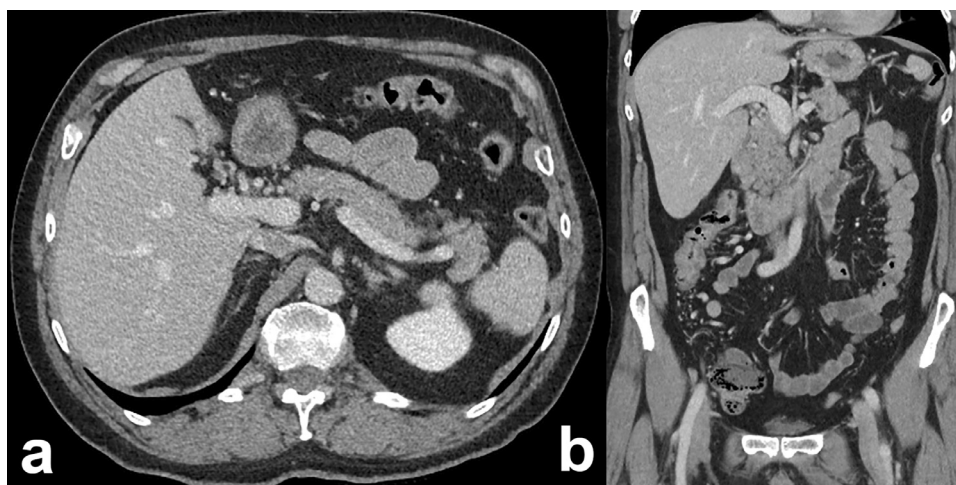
(A and B) Complete regression of the PVT in the CT after 12 months.
